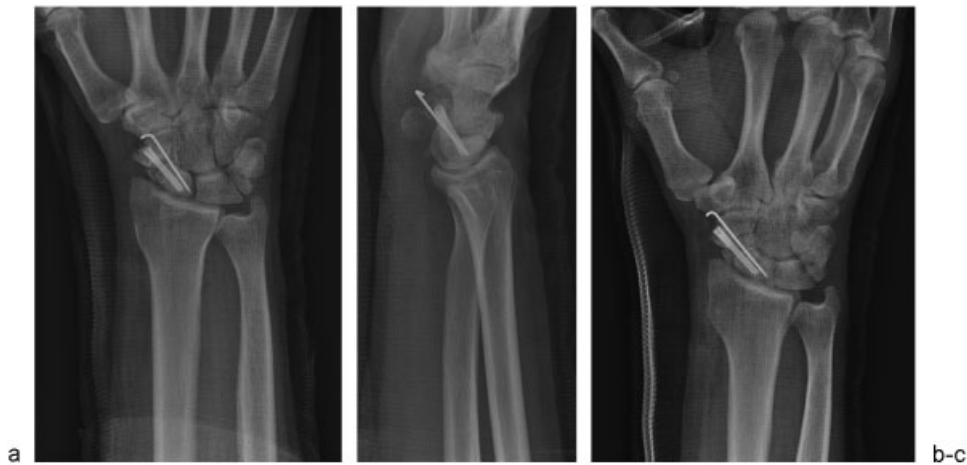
(a) Anteroposterior (b) lateral (c) and oblique radiographs demonstrating restoration of the scaphoid normal anatomy with placement of a structural graft. The construct is stabilized with a cannulated headless screw and a de-rotational Kirschner wire.
